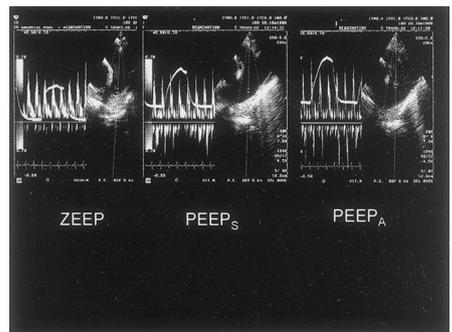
An example of a pulmonary artery Doppler flow recording at the three airway pressures. In these low-speed recordings, a large amplitude of cyclic change in peak velocity (*V_{max}*) was observed with zero end-expiratory pressure (ZEEP) and Amato's positive end-expiratory pressure (PEEP_A), whereas this amplitude was reduced with Suter's PEEP (PEEP_S).
